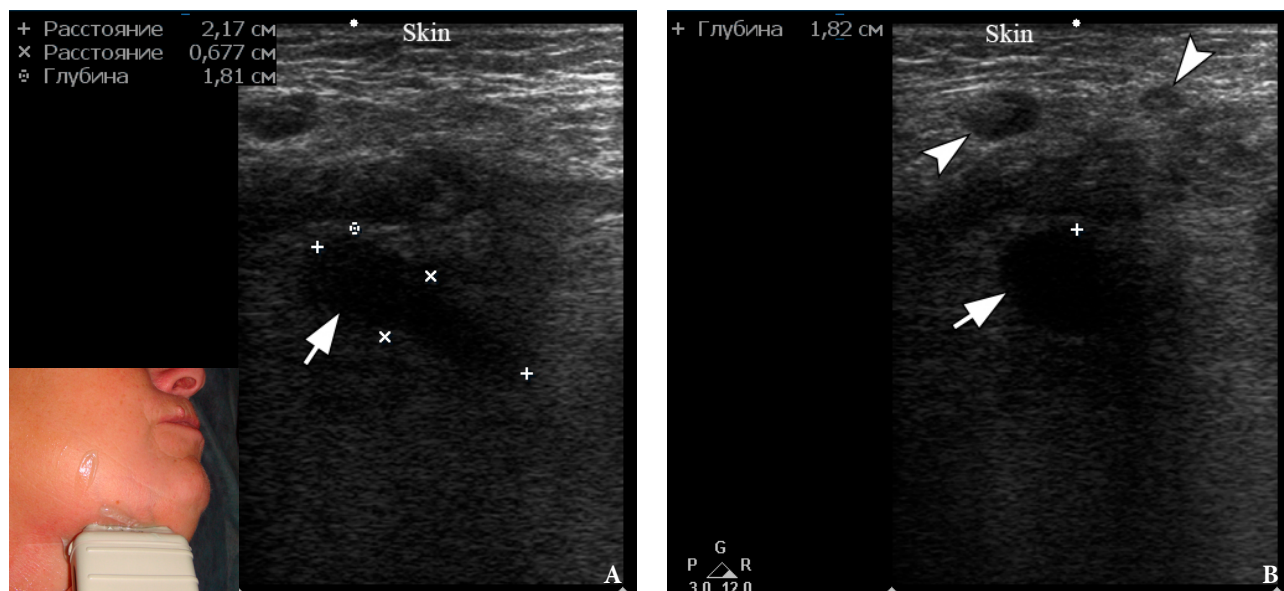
(A) The longitudinal gray scale ultrasound of the massively dilated right Wharton's duct (*arrow*) measured 2.17×0.67 cm. The length of the duct is indicated by "+" calipers and width is indicated by "x" calipers. Ultrasound appearance consistent with sialodochitis (also known as ductocele). (B) The transversal gray scale ultrasound shows a cross-section of the duct (*arrow*). *Arrowheads* label two reactive submandibular lymph nodes. The depth of the expanded duct from the skin surface is 1.82 cm and is marked with a "+" caliper. The "depth" of ultrasonography is 5.0 cm.
